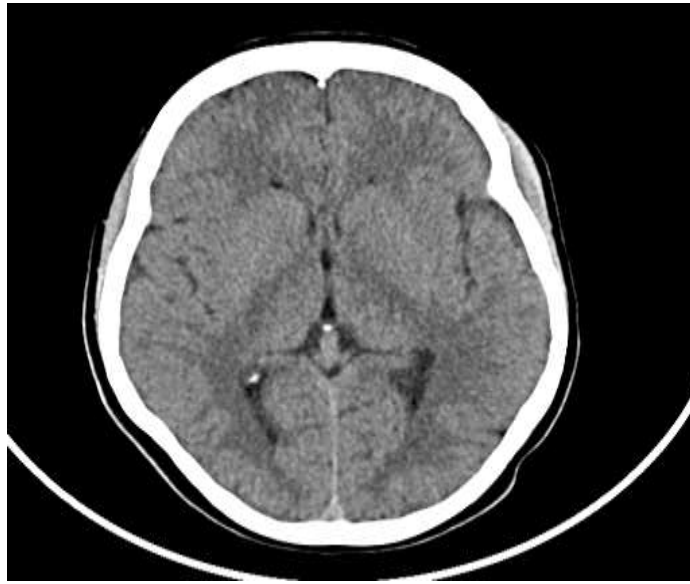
Axial head CT brain window of a 21 year old male who presented with chronic headache. CT scan was unremarkable.
